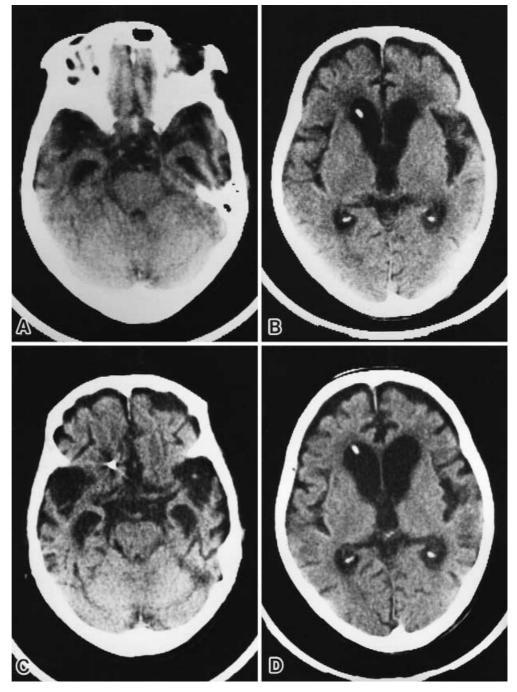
Brain computed tomography showing progressive atrophy of the bilateral temporal lobes. A, B About 9 years after disease onset, C, D about 14 years after disease onset
